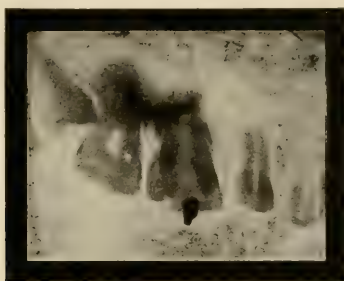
Impacted upper third molar, causing melancholia and insomnia. (Radiograph by Lodge, of Cleveland.)
